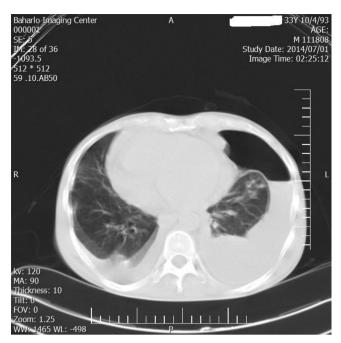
Axial noncontrast chest computed tomography (CT) image on day 0: showing large pneumothorax with pleural effusion.
